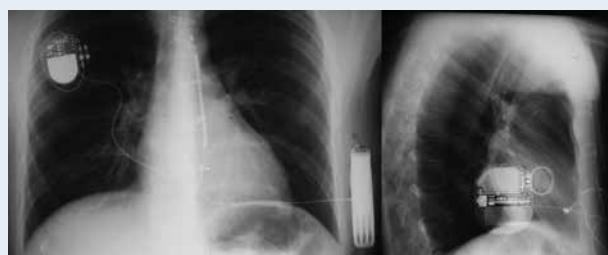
Chest X-ray of the patient with pacemaker connected to epicardial lead, artificial tricuspid valve and subcutaneous implantable cardioverter-defibrillator
